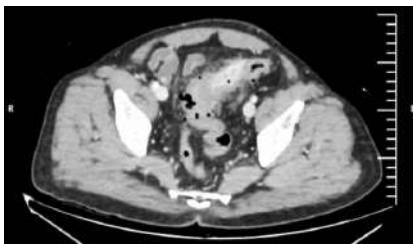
CT showing Localised perforation and long segment sigmoid diverticulitis
